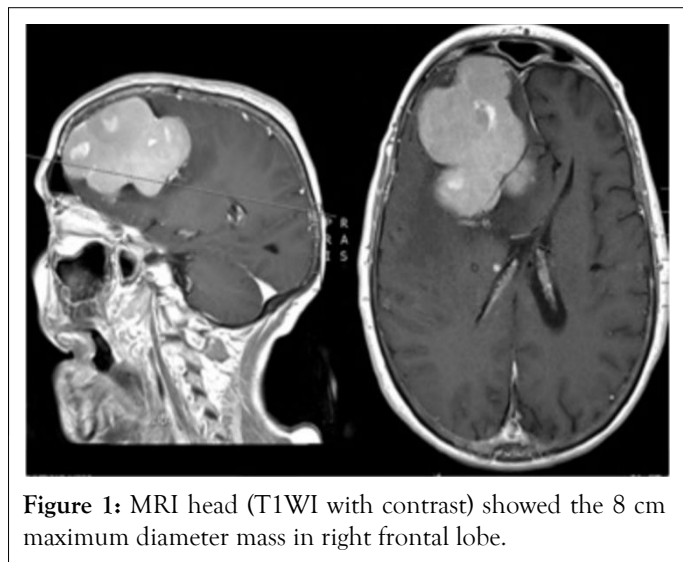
MRI head (T1WI with contrast) showed the 8 cm maximum diameter mass in right frontal lobe.
